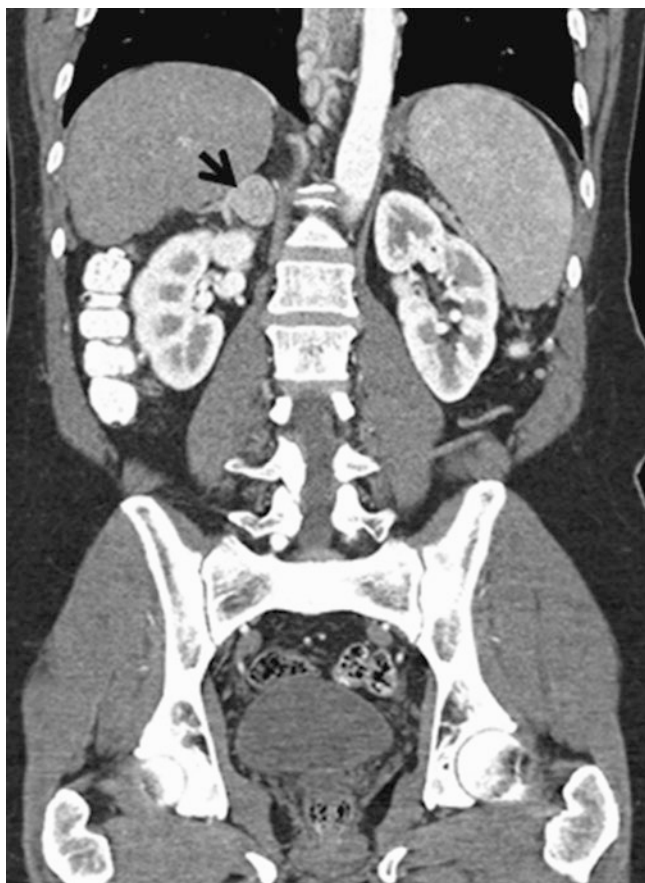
Coronal CT with an enhancing adrenal nodule consistent with pheochromocytoma
